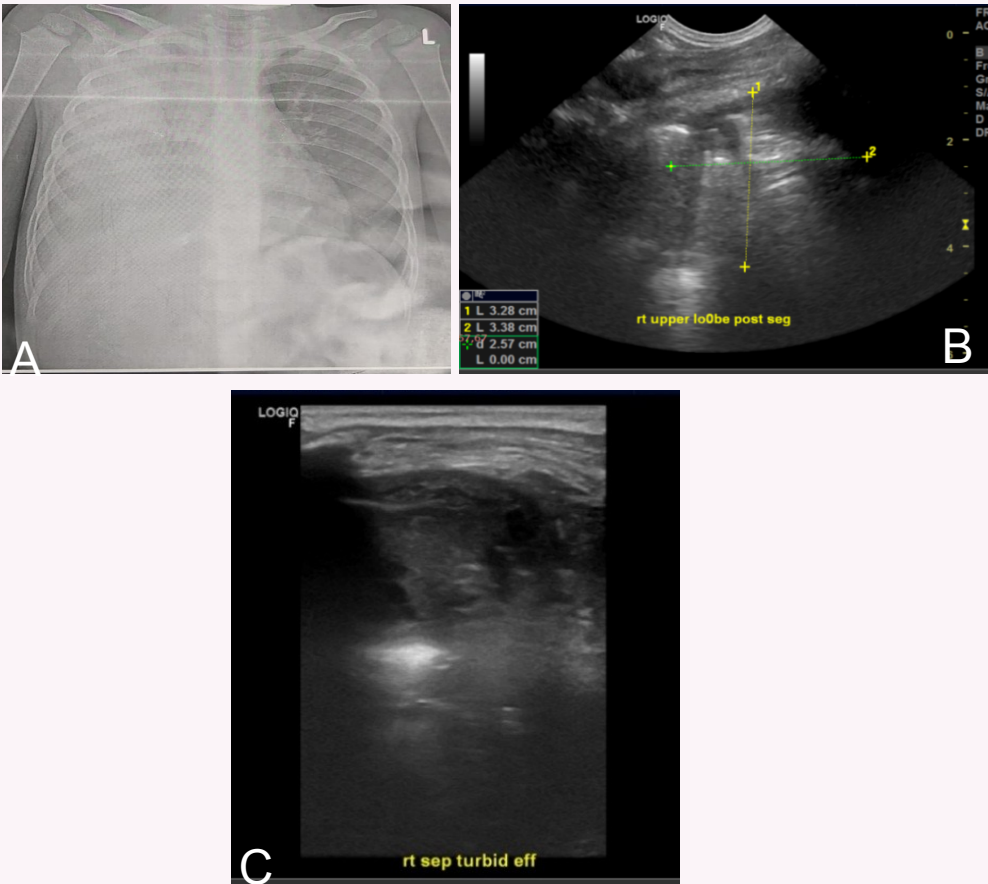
(a) Chest X-ray shows complete opacification of the right lung lobe "white lung". (b) lung ultrasound (LUS) performed at the same time demonstrates right upper posterior lobar consolidation averaging 3.2x3.3cm, (c) right moderate septated turbid pleural effusion... empyema.
